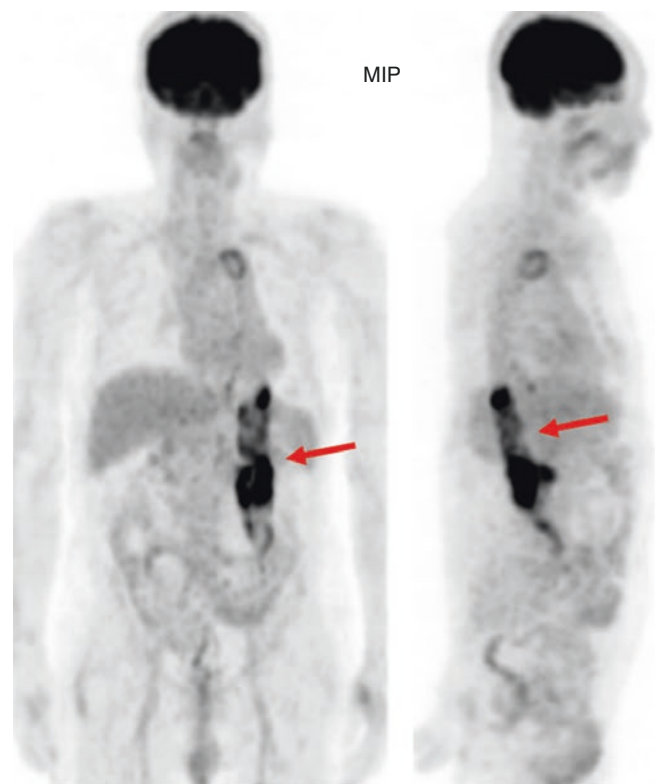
Anterior and lateral images of FDG-PET/CT with maximum intensity projection (MIP). High FDG uptake surrounding the aortic graft was observed from the diaphragm to the common iliac artery. Arrows indicated the lesion
